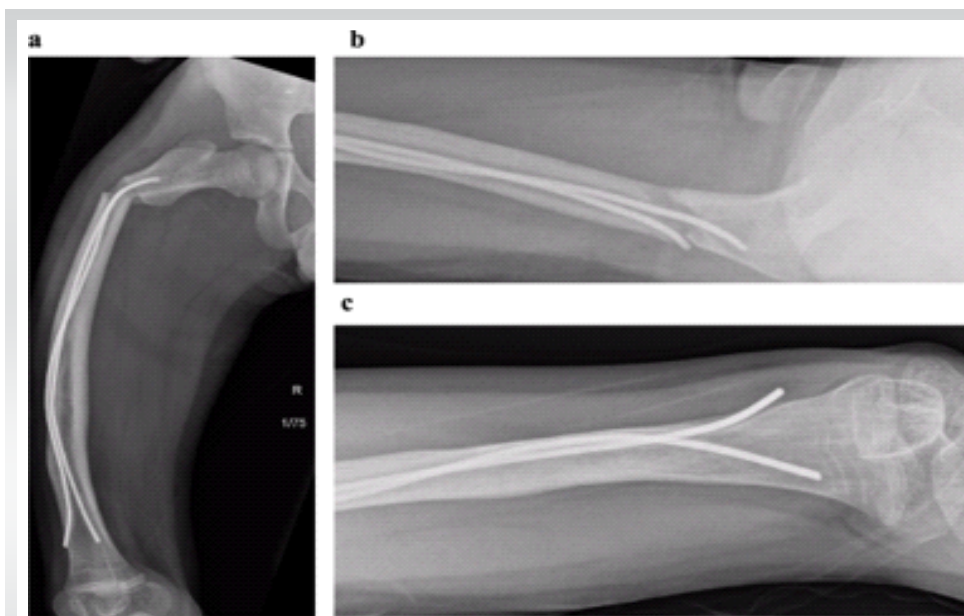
Pre-operative radiographs demonstrating atypical femoral fracture morphology with intramedullary rods in situ. Anteroposterior and lateral plain radiographs of the right femur were obtained at the time of fracture presentation. (a) Anteroposterior view demonstrating a mildly displaced subtrochanteric proximal femur fracture with moderate anterolateral angulation, occurring through the segment traversed by the pre-existing flexible intramedullary rods. (b) Lateral view demonstrating the same fracture with associated anterolateral angulation. (c) Distal femur view demonstrating endosteal bone formation and the diverging distal ends of the two flexible intramedullary rods. The short oblique fracture orientation, subtrochanteric location, and minimal trauma mechanism are consistent with an atypical femoral fracture per American Society for Bone and Mineral Research major diagnostic criteria.
